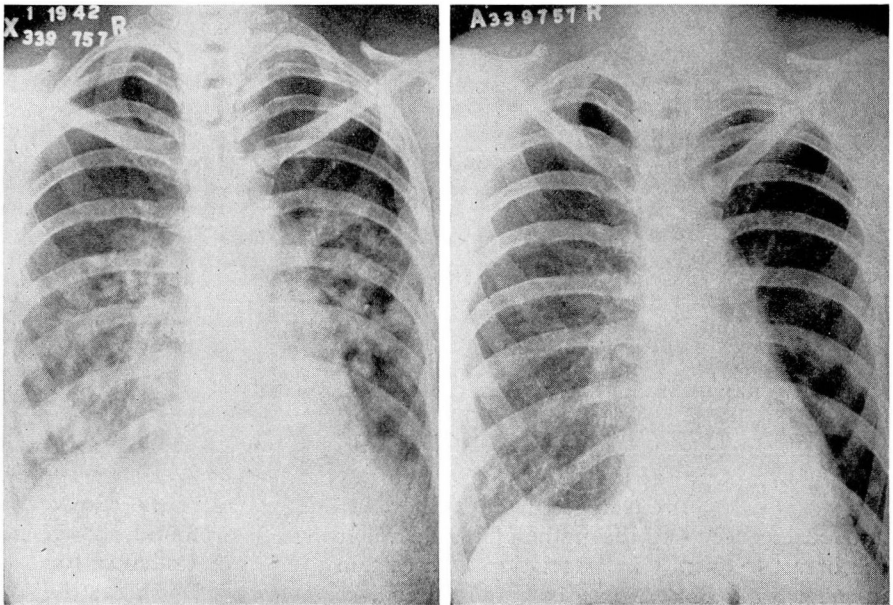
Regression of metastases from breast cancer in a woman 42 years old. Six months following x-ray therapy to ovarian region. Total skin dose 1650 r.
